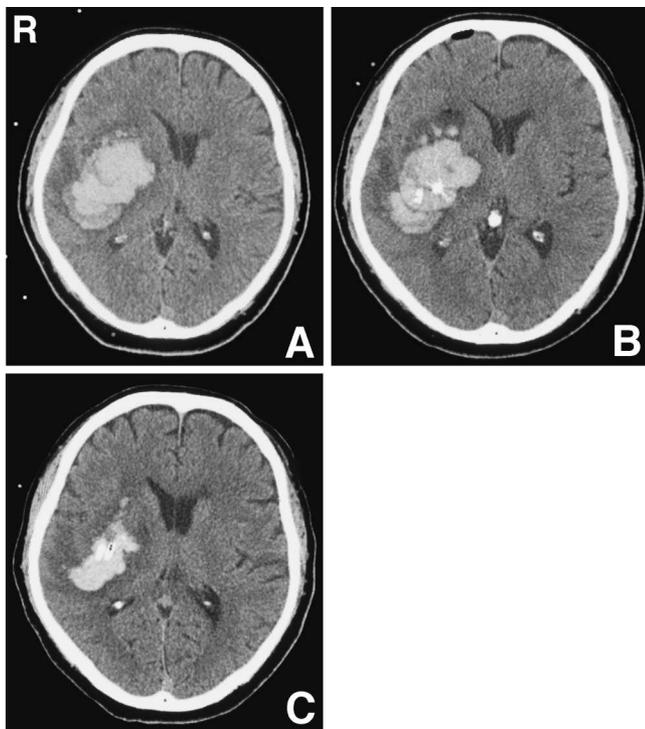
Computed tomography scans showing (A) right putaminal hemorrhage of 4×5 cm before stereotactic aspiration, (B) reduced size of the hematoma immediately after stereotactic aspiration, with the two catheter tips, and (C) decreased size of the hematoma after administration of urokinase.
